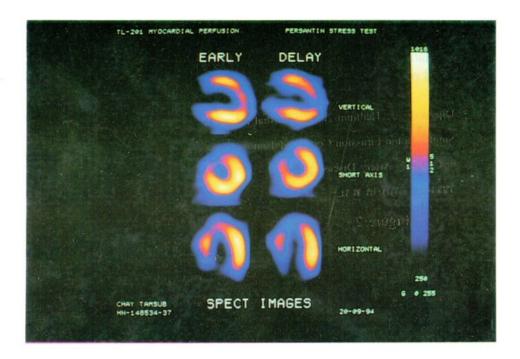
Dipyridamole stress and redistribution images of thalliuum-201myocardial perfusion SPECT study in a patient with coronary artery disease. Coronary arteriography showed 80% stenosis of the left main coronary artery, 70% stenosis of LAD, 65% stenosis of RCA and normal LCX. TI-201 myocardial perfusion images show fixed defects of apex, anterior wall and septum. The inferior and lateral walls look normal.
